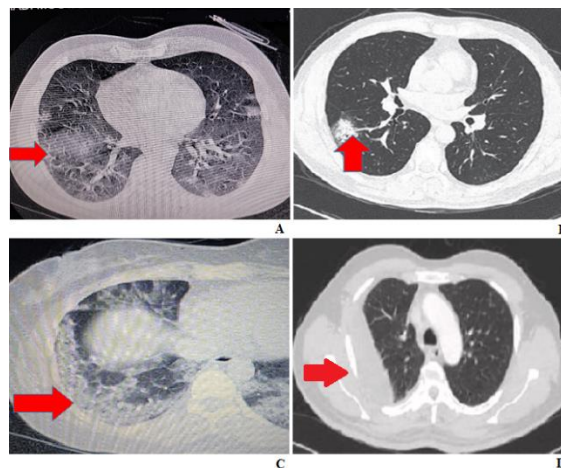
Examples of typical chest CT findings in patients with confirmed corona virus (A) axial chest CT of a 50-year-old man shows GGO, (B) axial chest CT of a 40-year-old woman shows GGO & consolidation, (C) axial chest CT of a 37-year-old woman shows crazy-paving pattern, (D) axial chest CT of a 60-year-old man shows pleural effusion.
